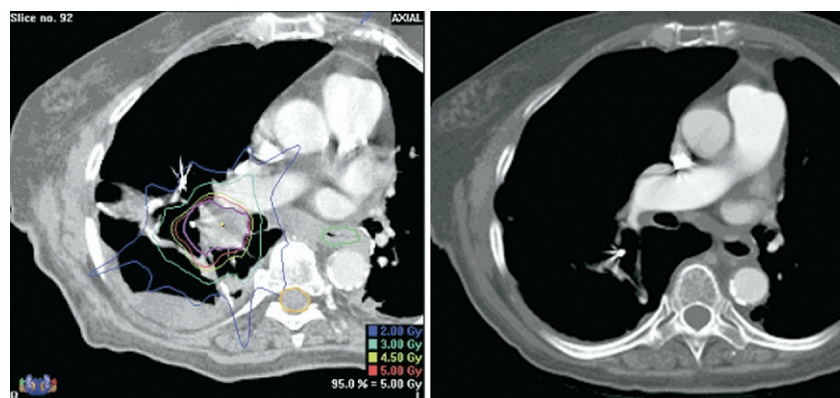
These computed tomography scans (CT) are of an 80-year-old female ex-smoker with a history of chronic obstructive pulmonary disease and a prior T2 N1 non-small cell lung cancer of the left lower lobe for which she received a left lower lobe sleeve resection and mediastinal chemoradiotherapy to 50.4 Gy in 1999. She presented in 2007 with another T2 N1 tumor now of the right lower lobe with compromised respiratory function. She underwent a wedge resection of the primary tumor and a course of reirradiation to the N1 lymph node agglomeration. (A) Represents the radiotherapy plan using the Novalis radiosurgical system (BrainLAB AG, Feldkirchen, Germany). (B) This CT scan 1 month after delivery of 50 Gy in 10 fractions reveals a complete radiologic response to the therapy.
